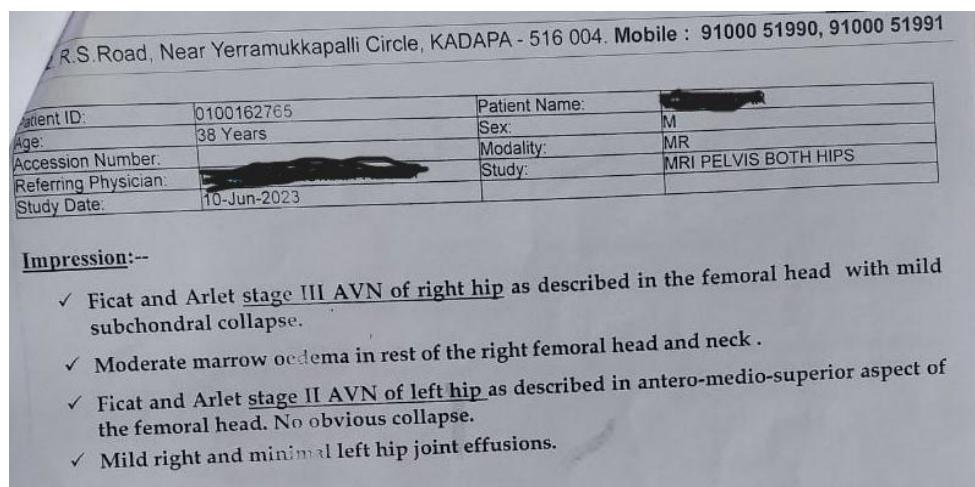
MRI Pelvis (Both Hips) dated 10-06-2023 showing features of bilateral Avascular Necrosis -Stage III (right hip) and Stage II (left hip)
